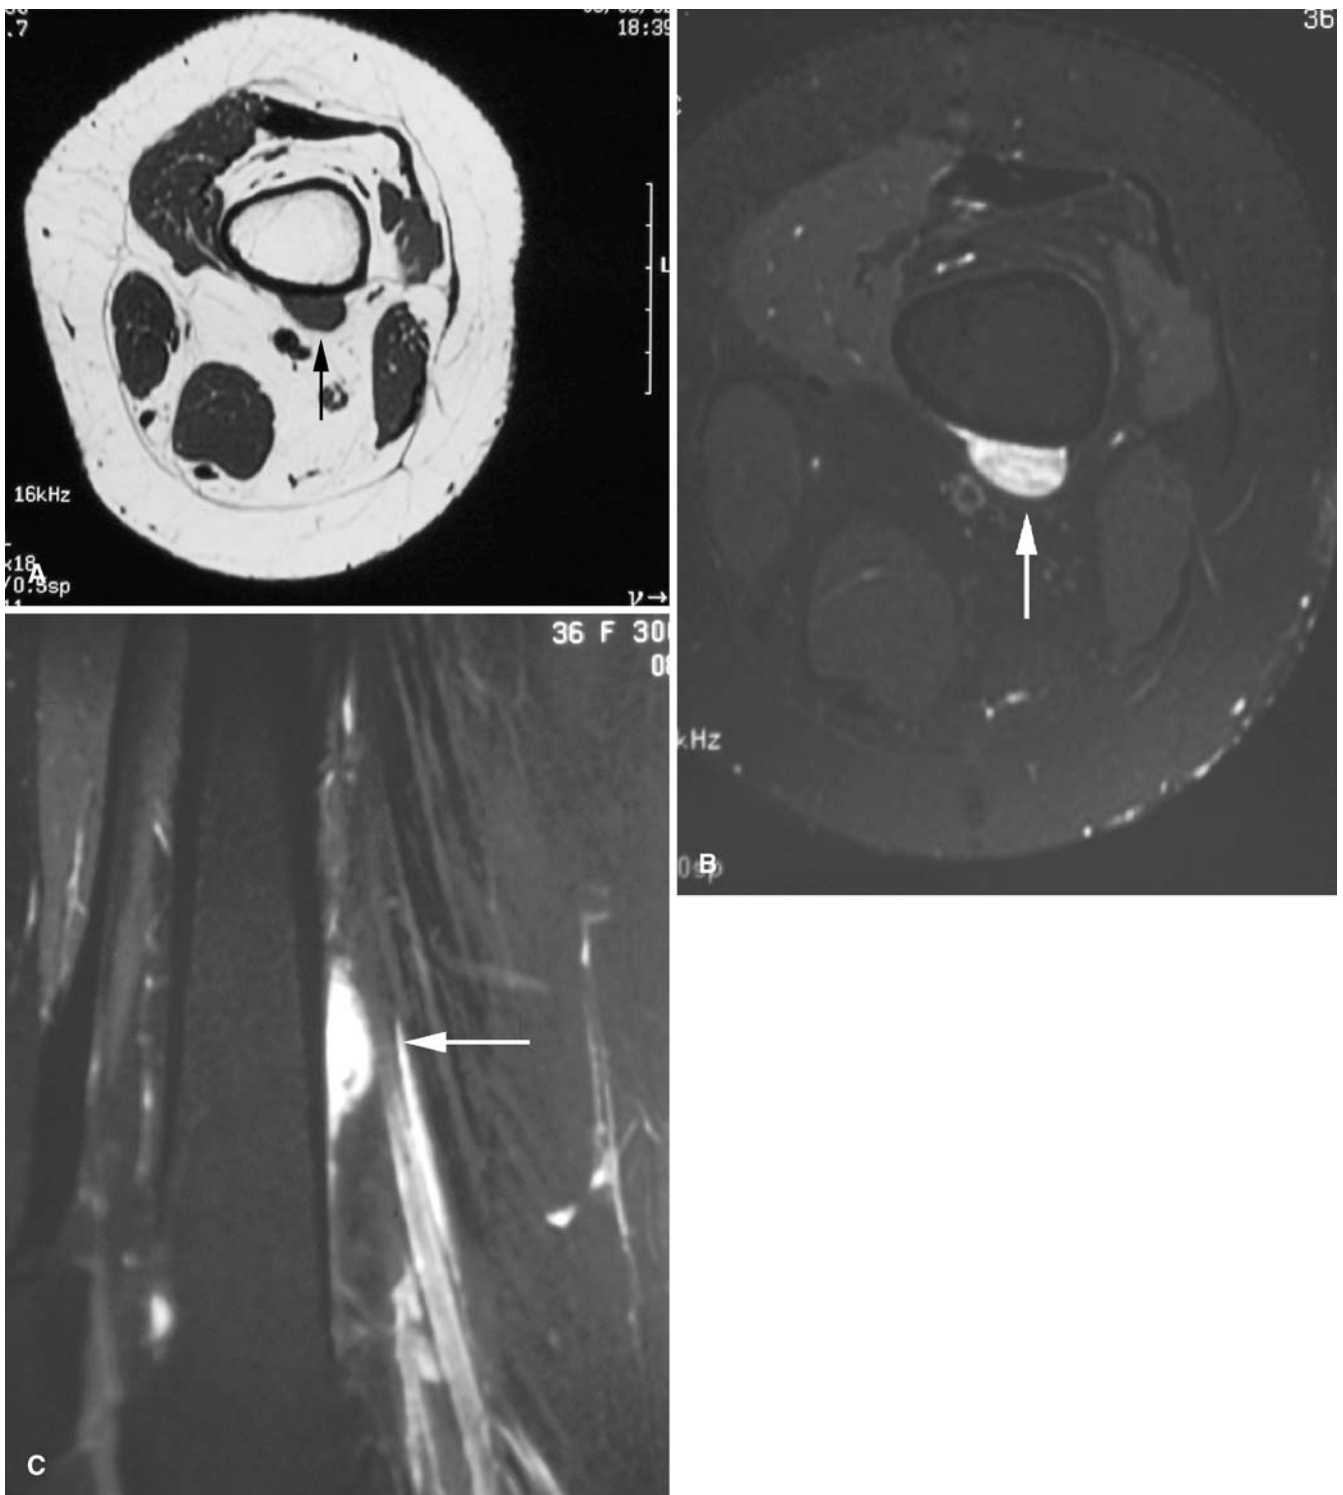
A Axial T1-weighted image (TR/TE 750/14) of the left mid-thigh revealed a low signal intensity (SI) mass confluent with the posterior cortex of the femur (*arrow*). B On a STIR sequence
